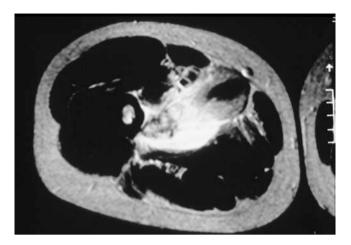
Myositis ossificans: T1 weighted MRI showing the absence of discrete mass and intermuscular extension. From: Brennan MF, Lewis JJ. *Diagnosis and Management of Soft Tissue Sarcoma*. London: Martin Dunitz Ltd., 1998
